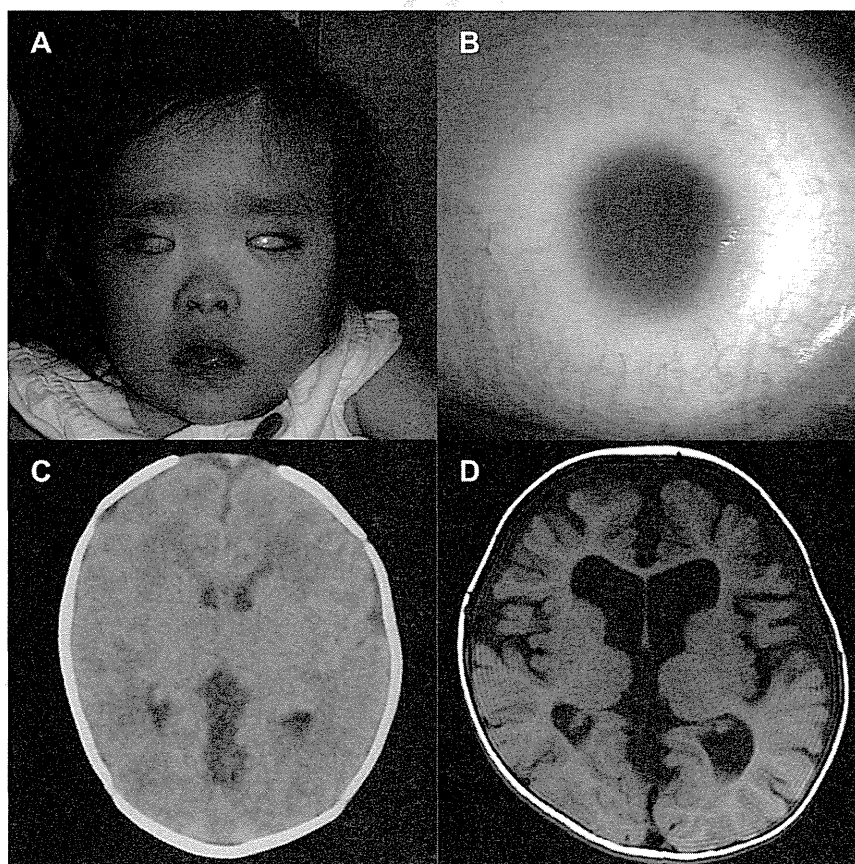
Clinical and radiographic features of the proband. A: Facial appearance of the proband. Note the prominent forehead, microphthalmia, thin upper lip, long palpebral fissures, and long eyelashes. B: Appearance of the left eye at the age of 2 years: extreme microcornea with an occluded pupil can be seen. C: Axial computed tomography at 2 weeks of age. Note the preserved white matter volume. D: Axial magnetic resonance imaging of the brain at 21 months of age, demonstrating significant global volume loss predominantly involving white matter.
